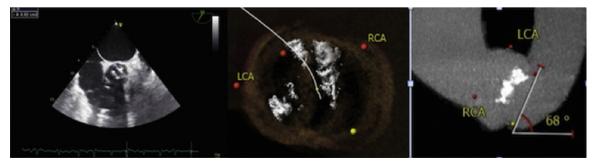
TEE (Left) and CTA (Middle) showing the congenital bicuspid aortic valve with a severe horizontal angulation (Right). Middle and right pictures from Medtronic company.
